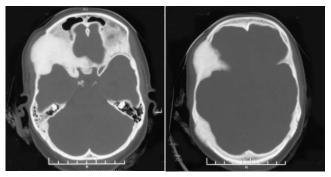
CT scan of the brain bone window showed Hyperostosis in right sphenoidal and right Occipitoparietal bone
